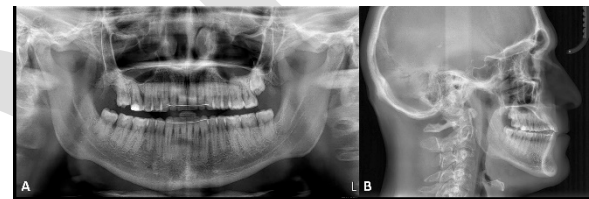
Pre-treatment radiographs of the patient. A, Panoramic radiograph; B, Lateral cephalometric radiograph.
